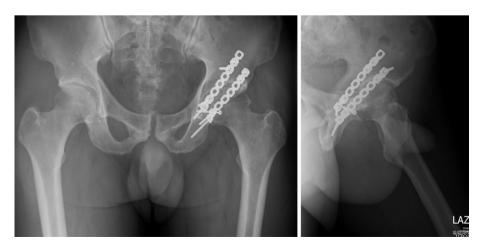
X-ray of the pelvis 1 year after surgery showed good alignment of the left acetabulum. There is no evidence of dislocation or subluxation of the femoral head.
